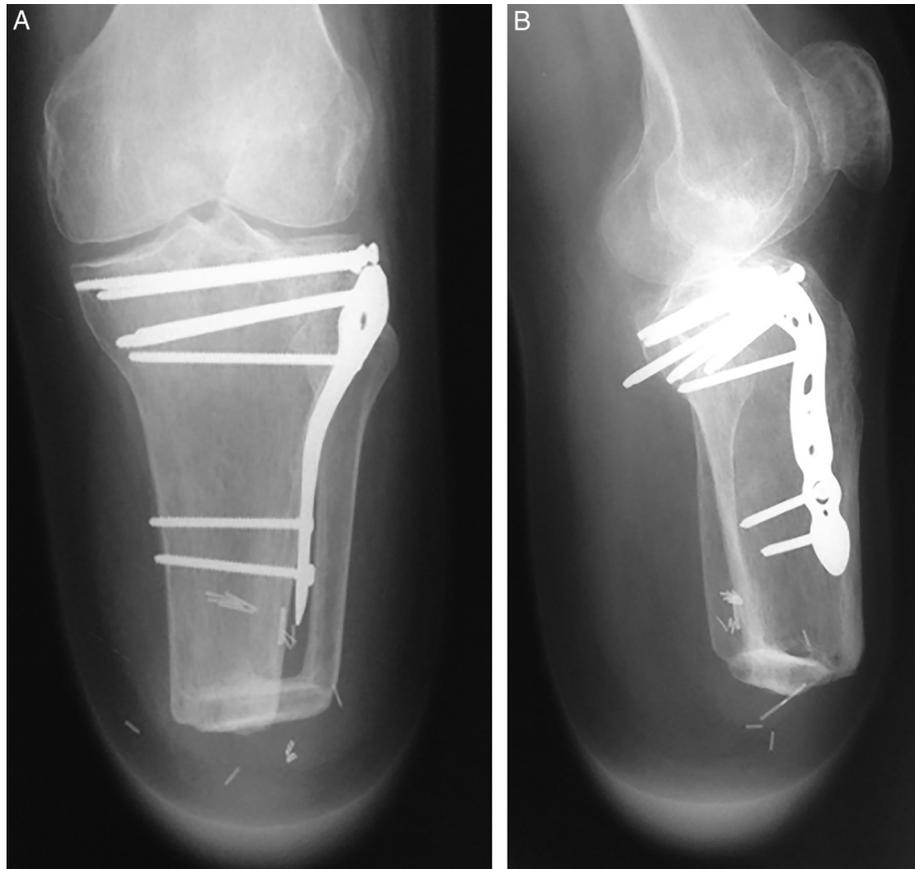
(A) Anteroposterior and (B) lateral radiographs of the left knee at 26 months of follow-up demonstrating full consolidation of the bony bridge.
